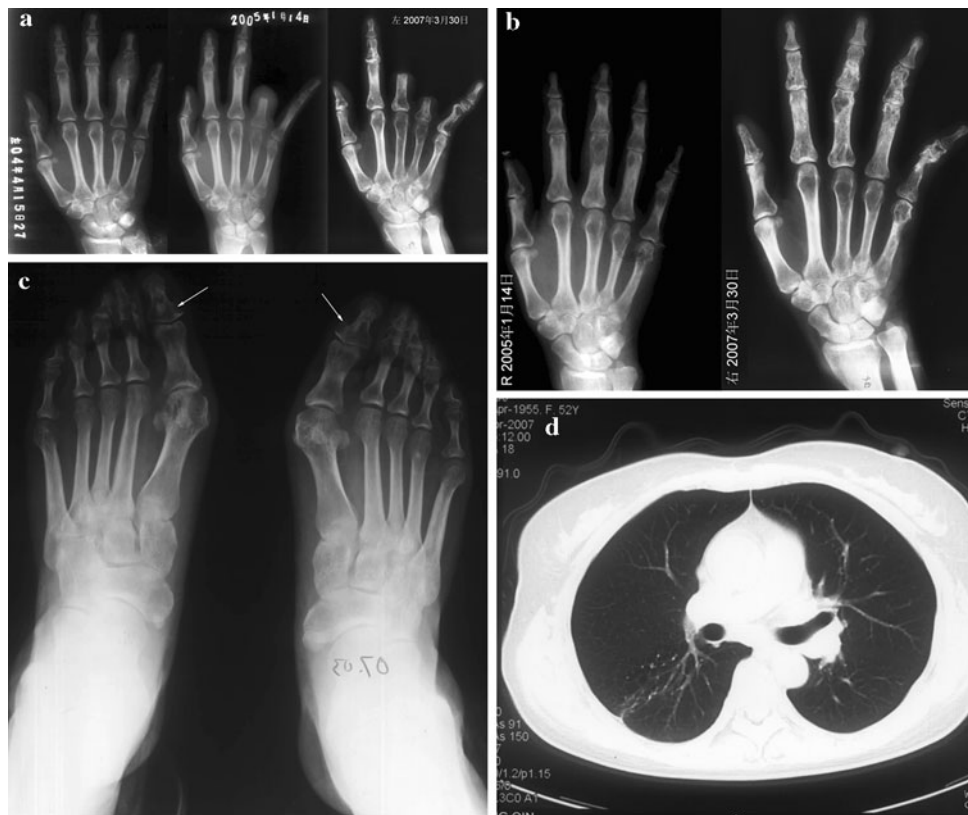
a The development of left hand X-ray from April 2004 to March 2007. In April 2004, radiography of fourth finger on left hand showing extensive cortical bone destruction. Extensive soft-tissue swelling is also present. In January 2005, after operation showing loss of cortical bone in the third finger, absence of fourth finger. In March 2007, after second operation a year later showing loss of cortical bone in the second and fifth finger of the left hand, absence of midpiece of middle and ring finger of the left hand. Extensive soft-tissue swelling
